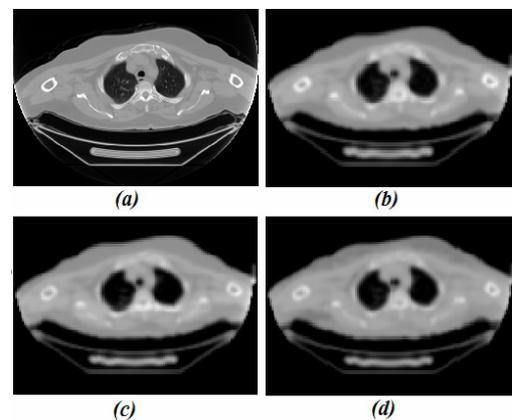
Original patient CT image (a) and generated attenuation maps using bilinear (b), dual energy (80 and 140 kVps) (c) and virtual dual-energy (d)
